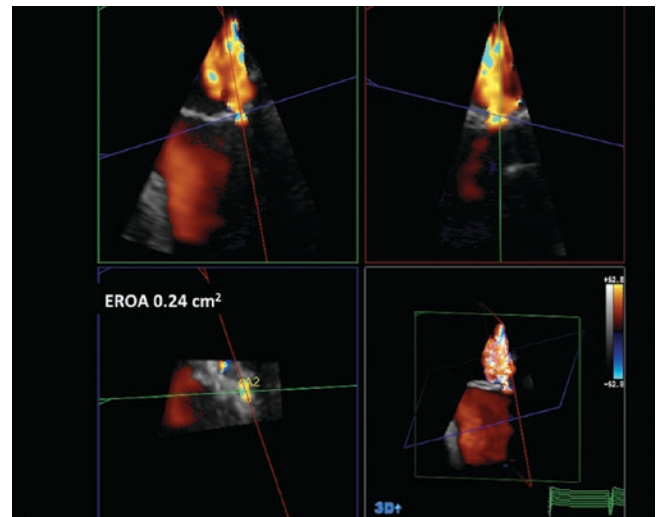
3D echocardiography can be utilized to measure the EROA. One can align orthogonal planes to the regurgitant jet to identify the EROA. The EROA can then be traced. In this figure, the EROA can be visualized en face and reveals an area of 0.24 cm²
